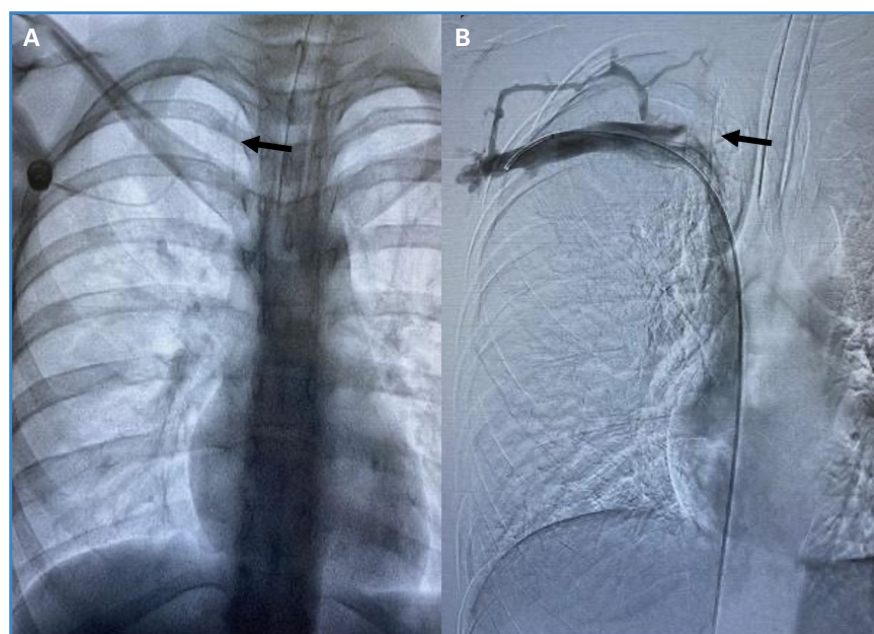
A. Anteroposterior X-ray showing the fractured catheter segment (black arrow). B. Fluoroscopic venography showing the catheter segment (black arrow) in the jugular-subclavian confluence and superior vena cava inside the thrombus.
